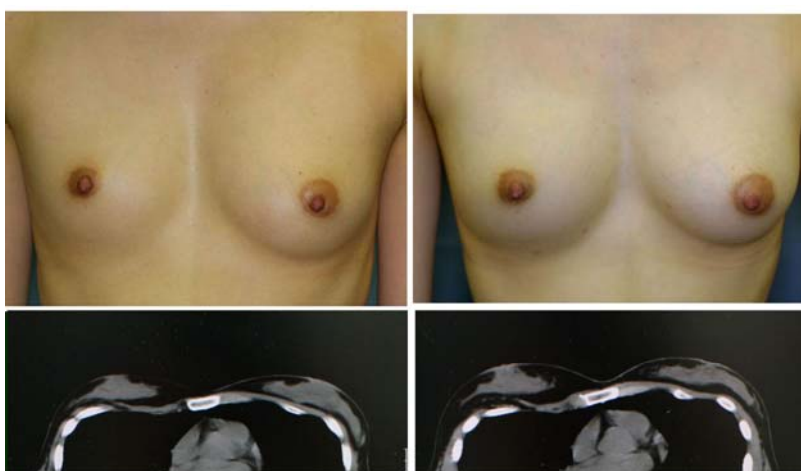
Case 4 (Inborn deformity treated with full-CAL): A 26-year-old woman, who had a hypoplastic breast along with thoracic deformity on the right side, underwent CAL augmentation for both sides (325 ml and 105 ml on the right and left, respectively) Preoperative (left panels) and postoperative (right panels) views at 12 months. Both breasts were significantly improved without any indurations detected. A few small injection scars on the inframammary folds are left, but nearly invisible. Pre- and post-operative CT scans (bottom, left and right) show that adipose tissues were augmented not only subcutaneously but also under the mammary glands with no abnormal nodules or calcifications detected.
